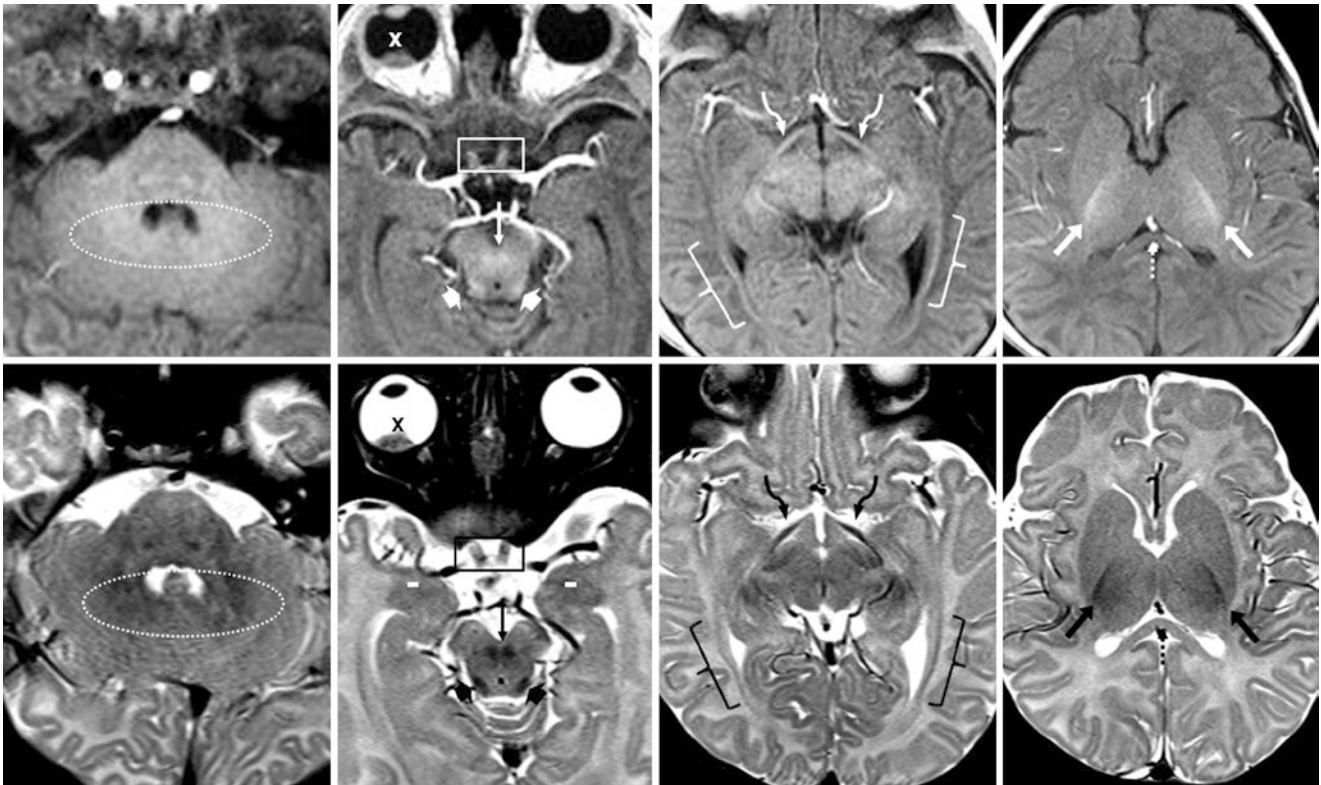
A 6-week-old with a normal 1.5T MRI obtained for suspected retinoblastoma (X). Both spoiled GE T1WIs (*top row*) and SE T2WIs (*bottom row*) depict myelinated cerebellar white matter and nodulus (*dotted ovals*), inferior colliculi (*wide arrows*), DSCP (*thin arrows*), optic tracts (*curved arrows*), optic nerves (*boxes*), and PLICs
